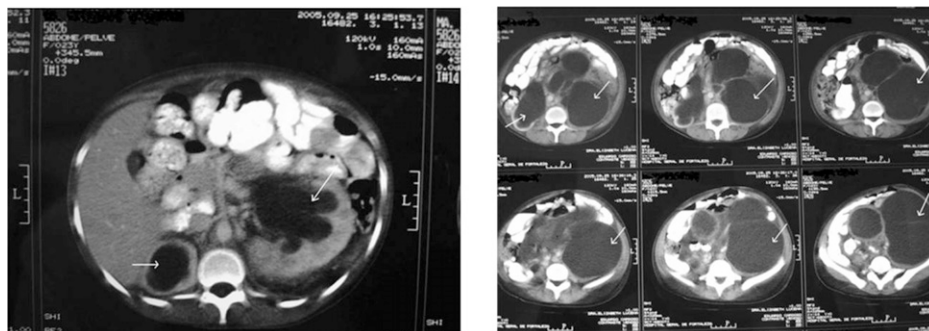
Computed tomographic image of a patient with renal tuberculosis showing enlargement of both kidneys, cortical thinning with low density, markedly dilated calyces, and severe dilation of ureter (megaureter). Adapted with permission from Daher et al.²⁴
